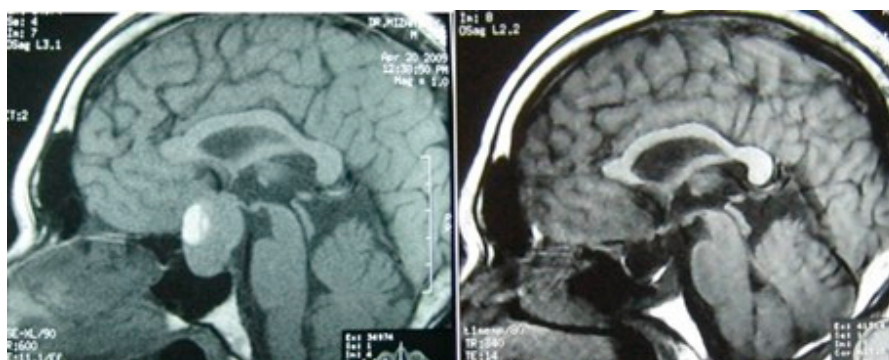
Non-functioning macroadenomas usually present with visual symptoms due to their suprasellar extension. MRI of brain sagittal sections in TW1. (left) preoperative image showing pituitary macroadenoma; (right) postoperative image showing excision of tumour. Source: Figure by authors.
